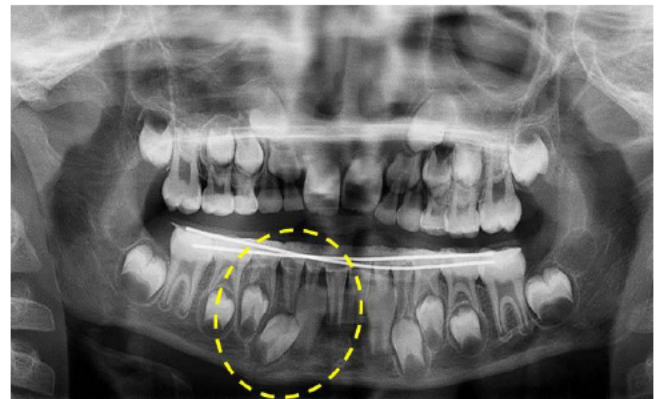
Orthopantomograph after 7 weeks
